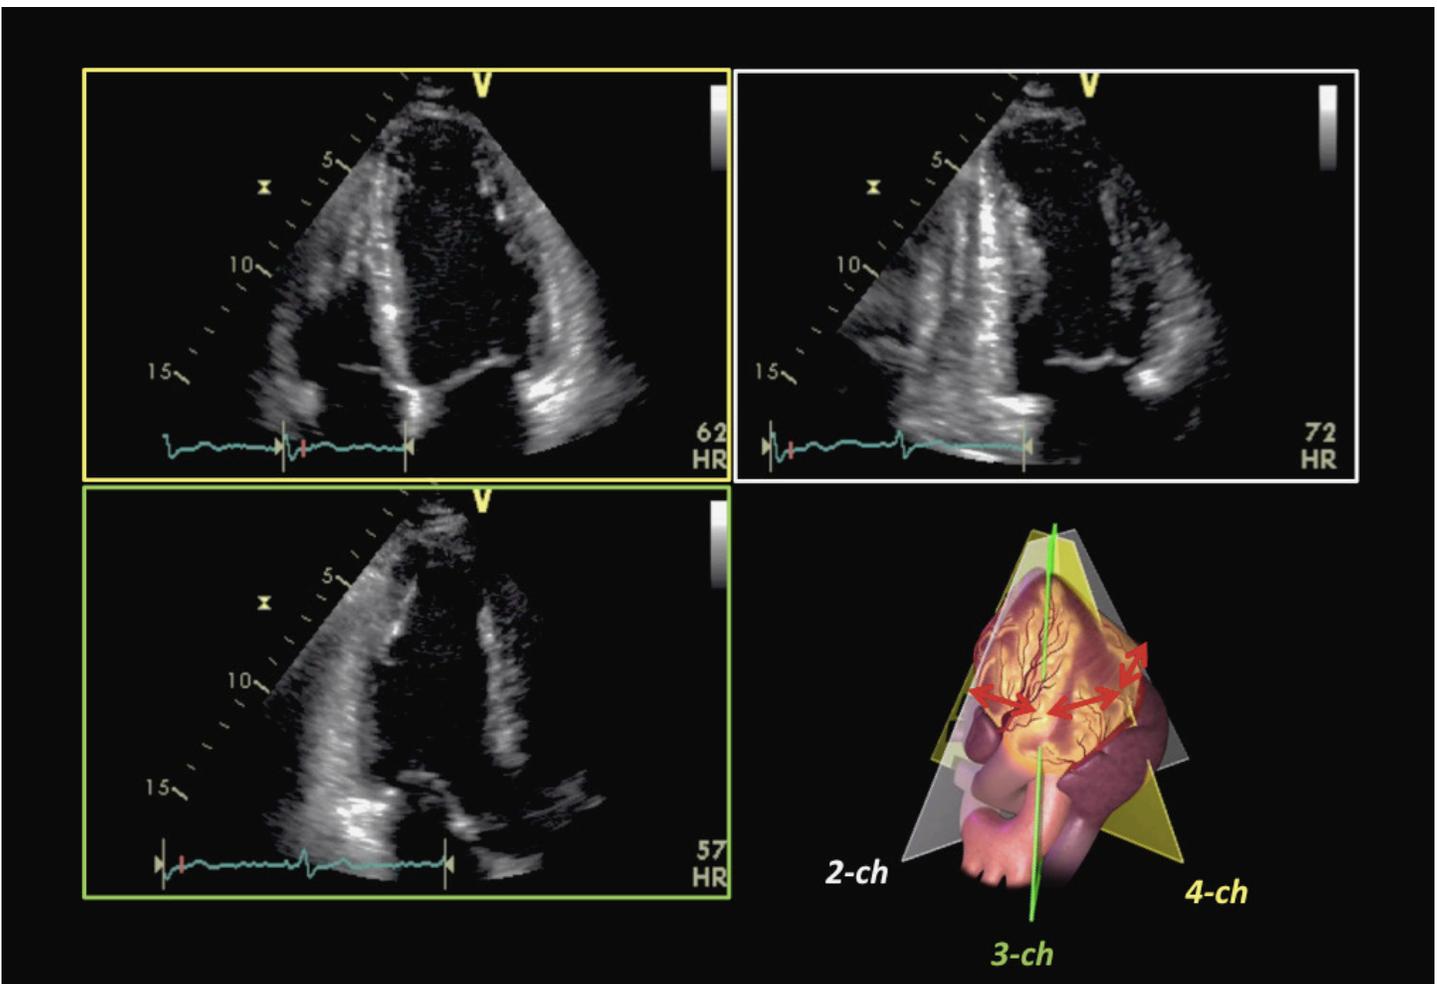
Echocardiographic two-dimensional (2D) acquisitions of the left ventricle for 2D longitudinal strain analysis. The three apical 2D views (4-chamber – yellow quadrant, two-chamber – white quadrant, and long-axis – green quadrant) display only a very limited part of the myocardium, which is confined in three thin slices sharing the same longitudinal axis of the left ventricle (bottom right). As a consequence, longitudinal strain analysis by 2D speckle-tracking (AFI/2D Strain): (I) reflects deformation abnormalities only if they are captured by the three standard 2D slices, and may miss them if the pathologic area lies in between views (red arrows); (II) is highly dependent on the cut-plane used in the 2D acquisition (since there are no precise anatomical references for the three views, slightly different cut-planes of the left ventricle by probe rotation or apical foreshortening may show the same pathologic area in various extents and, hence, with different strain results). In contrast, 3D volumetric acquisition of the left ventricle enabling speckle-tracking in the 3D space obviates for these issues.
